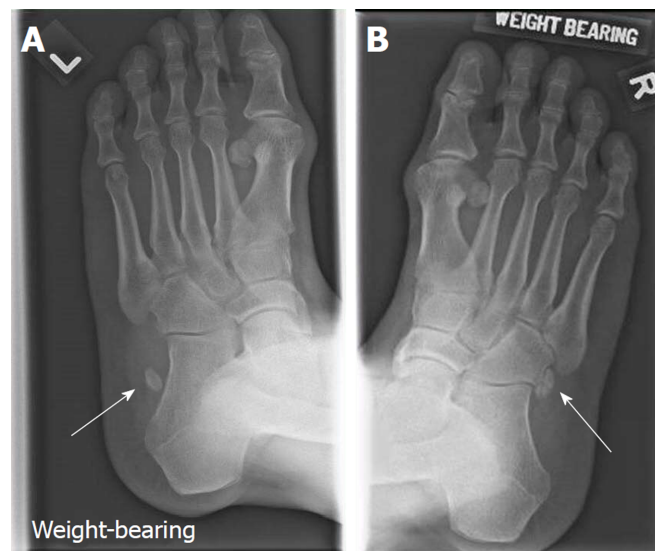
Comparing radiographs of bilateral oblique foot views. A: Weight-bearing oblique view of left foot show a bony fragment lateral to the anterior left calcaneum; B: Shows the position of the undisplaced os peroneum on the right foot. The displaced os peroneum over the left foot is better appreciated when compared against the contralateral foot.
